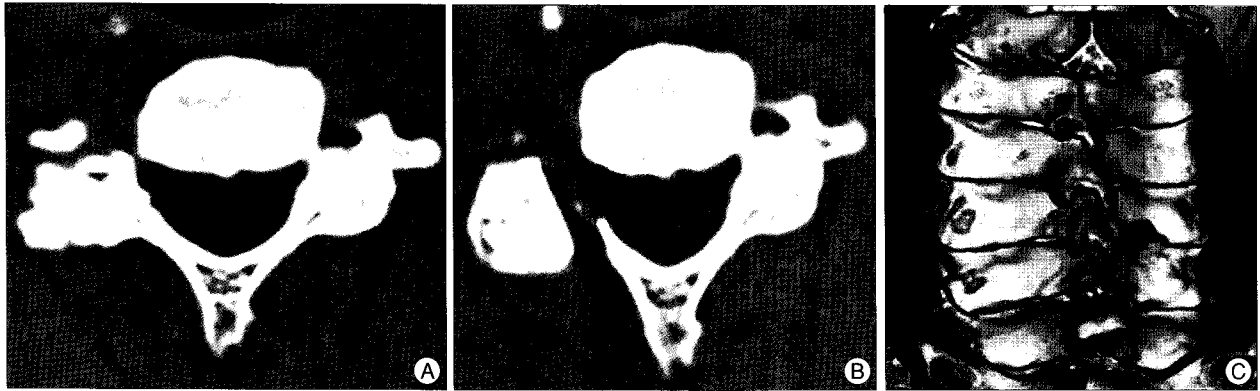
The preoperative and postoperative computerized tomography (CT). A : Preoperative axial CT shows foraminal stenosis with severe spondylosis in right facet joint. B : Postoperative axial CT shows a widen foramen with preservation of the facet joint after inclinary foraminotomy. C : Postoperative 3-dimensional reconstruction CT shows enough decompression of neural foramen with minimal facetectomy.
